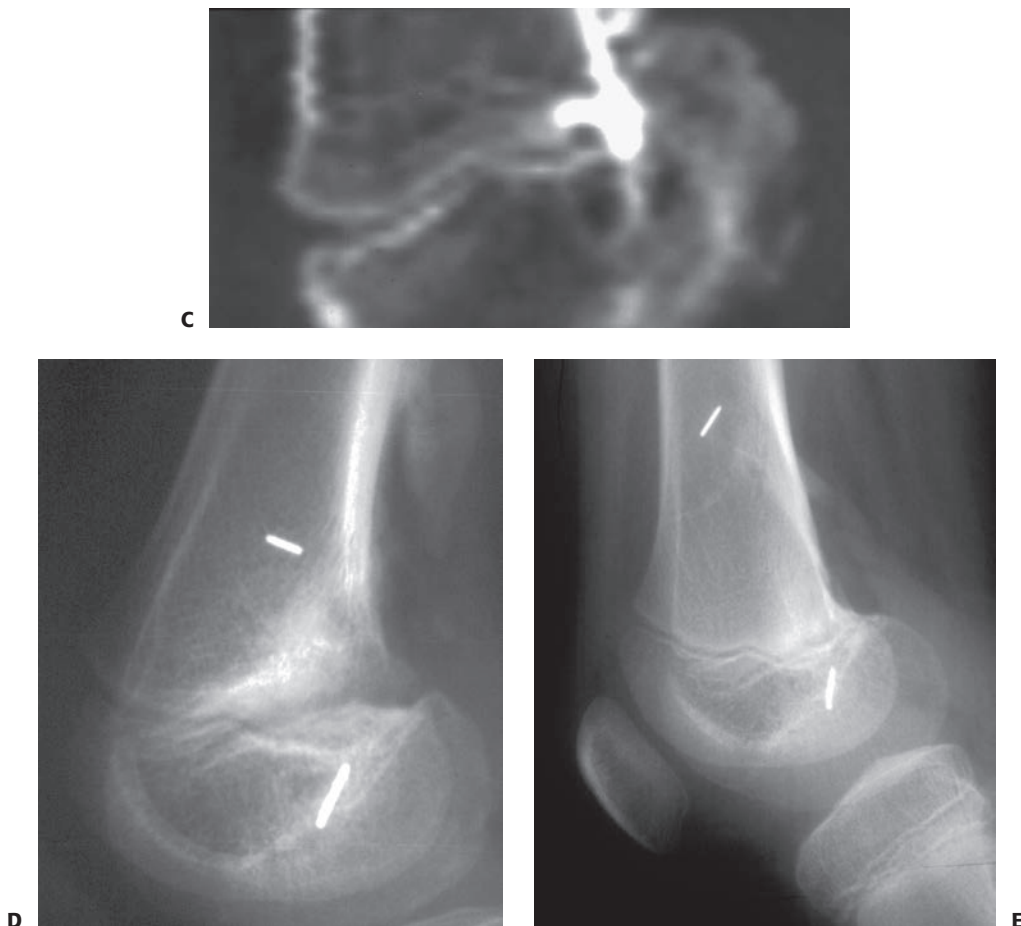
(continued) C: The posterior location of the partial arrest can be seen on the sagittal CT reconstructions. D: After arrest resection through a metaphyseal window, a cavity is evident in the region of the original bar. Metallic markers have been placed in the metaphysis and epiphysis. E: Three years after arrest resection, substantial growth has occurred, as documented by the increased distance between the markers. However, on radiographs taken at 4 years postoperatively, no further growth was documented. This event was treated by completion of the epiphysiodesis and contralateral distal femoral epiphysiodesis to prevent the development of limb length discrepancy from developing.
